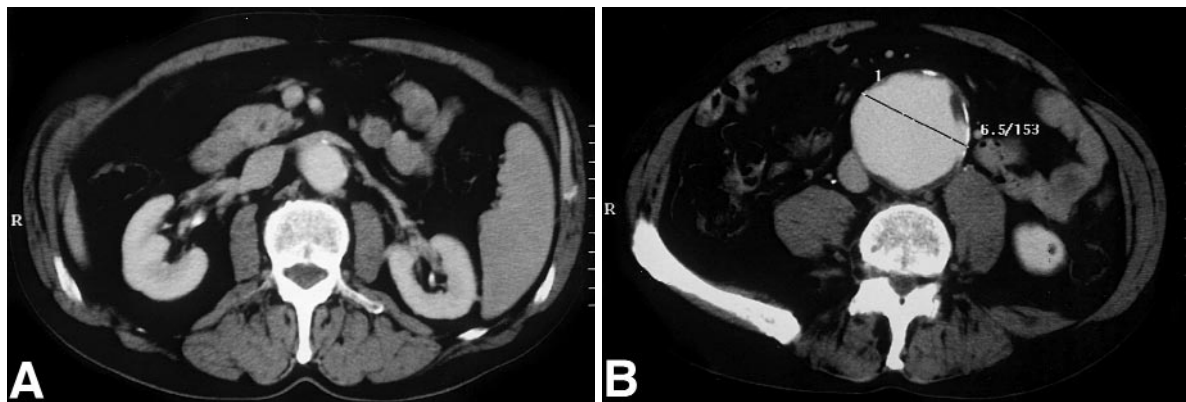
Preoperative computed tomography scan showing the cephalad neck (A) and the aneurysm sac (B) of the AAA before endoluminal treatment.
